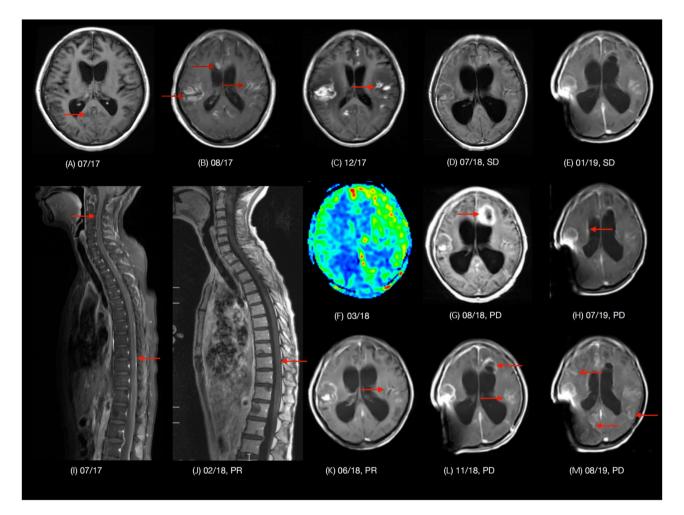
Representative MRI images during the clinical course of the patient. (A) Brain MRI at the time of leptomeningeal disease diagnosis. (B) At 5 days after WBRT, with enlarged region of enhancement due to increased blood-brain barrier permeability by WBRT. (C) Intracranial SD indicated by the highlighted areas on the imaging scans that have not notably changed in size or intensity. (D) SD indicated by the highlighted areas on the imaging scans that have not notably changed in size or intensity. (D) SD indicated by the highlighted areas on the imaging scans that have not notably changed in size or intensity. (F) Radiation-induced brain injury confirmed by arterial spin labeling MRI perfusion. (G) PD indicated by new lesion in left frontal lobe. (H) New lesion found in right lateral ventricle wall. (I) Spinal MRI at the time of leptomeningeal disease diagnosis. (J) Spinal MRI at 6 months after WBRT. (K) Shrunk region of enhancement compared with MRI in Dec 2017. (L) Enlarged enhancement region. (M) New lesions found appearing as bright areas on the MRI scan. Red arrows indicate intracranial lesions. MRI, magnetic resonance imaging; WBRT, whole brain radiation therapy; PR, partial response; SD, stable disease; PD, progressive disease.
